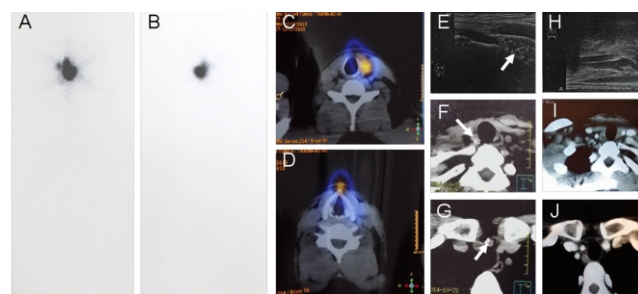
A 32 years old male in our department with papillary thyroid cancer and non ^{131}I -avid lymph nodes metastases after initial surgery who had a complete response after reoperation. Anterior: A) and posterior: B) therapeutic WBS 5 days after the administration of 555MBq ^{131}I showed a "hot spot" in the neck with a stimulated serum Tg of 15.93ng/mL and normal TgAb level. SPET/CT fusion image revealed only remnants in the left thyroid lobe: C) and the pyramidal lobe: D). However, calcified lymph nodes (arrow) were detected by ultrasonography: E) and plane CT: F) and G) indicating possible metastases. Pathologic examination of resected lymph nodes verified lymph node metastases from papillary thyroid cancer. Two months later, another ultrasonography: H) and enhanced CT: I) and J) were negative with an undetectable stimulated serum Tg level <0.04ng/mL and a normal TgAb.
